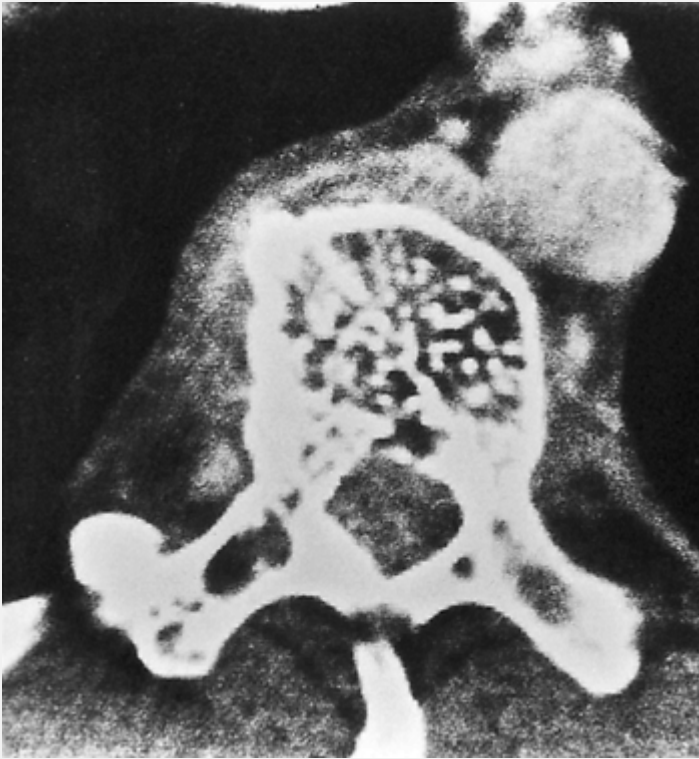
Vertebral hemangioma. A 39-year-old woman presented with back pain and decreased sensation and strength in the right upper extremity. Anteroposterior (A) and lateral (B) radiographs of the thoracic spine show a radiolucent lesion involving the body of T-6 and extending into the pedicle. (C) Lateral tomographic cut demonstrates ballooning of the posterior cortex of the vertebra and extension of the lesion into the posterior elements. (D) CT shows a soft-tissue mass encroaching on the spinal canal and displacing the spinal cord. Biopsy revealed a hemangioma. (From Greenspan A, et al., 1983, with permission.)
